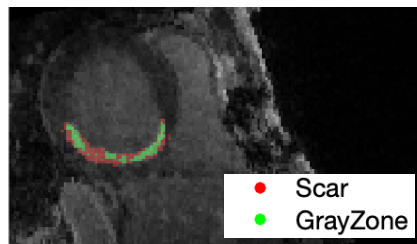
Example of an image from the MRI dataset showing the heart's short-axis plane. The left ventricle myocardium borders are outlined in white and the tissue areas identified with the 2-6 SD method, S and GZ are highlighted in red and green respectively.
